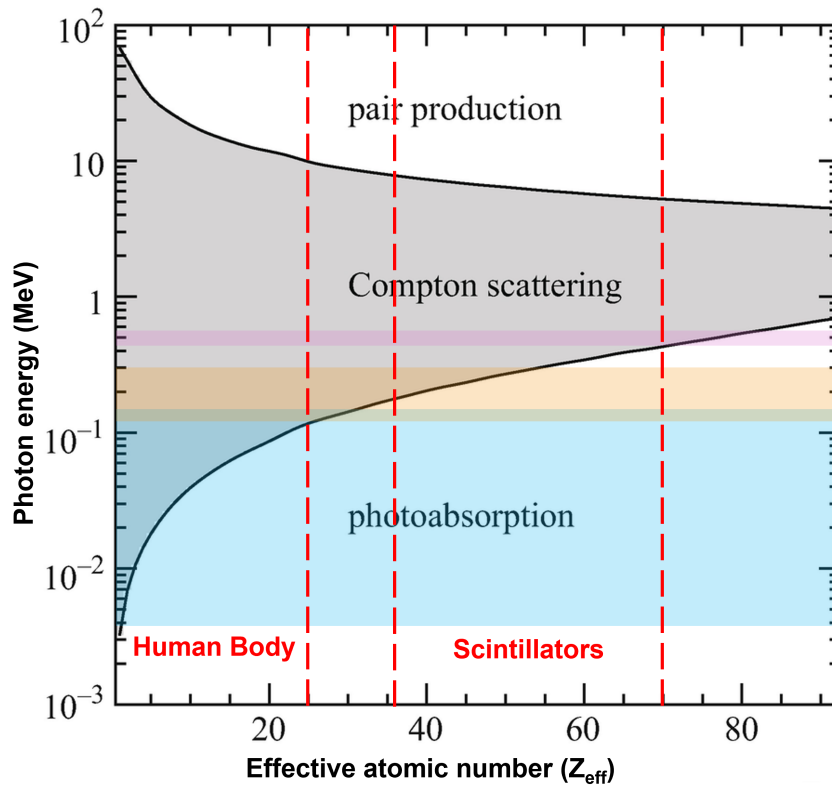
The various interactions of photons with matter based on their energies. The blue region highlights the energy range for medical X-rays, while the orange region indicates the energy range for SPECT, and the pink region marks the PET energy range (511 keV). The typical effective atomic number for human tissue is below 22, whereas for scintillator materials it ranges between 35 and 70. This figure is modified from C. Fabjan's *The Interaction of Radiation with Matter*, licensed under CC BY 4.0 (<https://creativecommons.org/licenses/by/4.0/>), source: [23].
